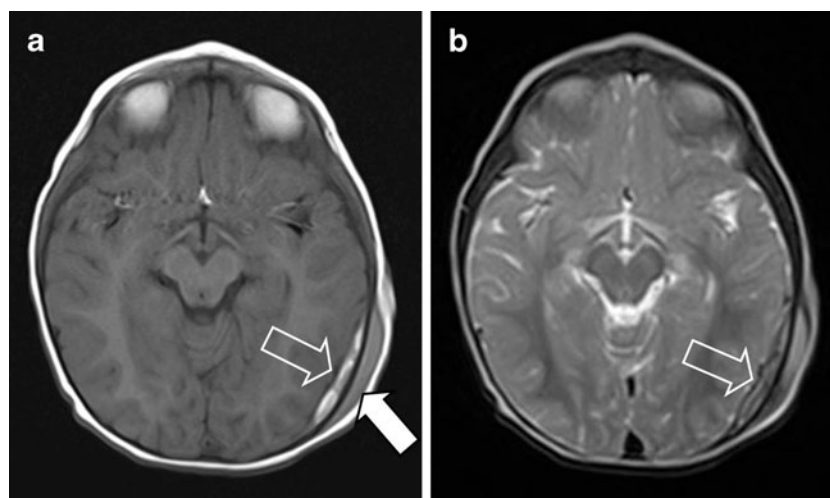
a Case 6. Axial T1-weighted MR image of a 1-year-and-3-month-old boy who fell from a bunk bed. *Information not available to the participating radiologists:* the history revealed that the boy was put on a bed (1.60 m high) by a sibling. He fell off and cried immediately; parents took him to the GP but were referred to the ED because of swelling on the head. The child was admitted to the pediatric ward for one night for
